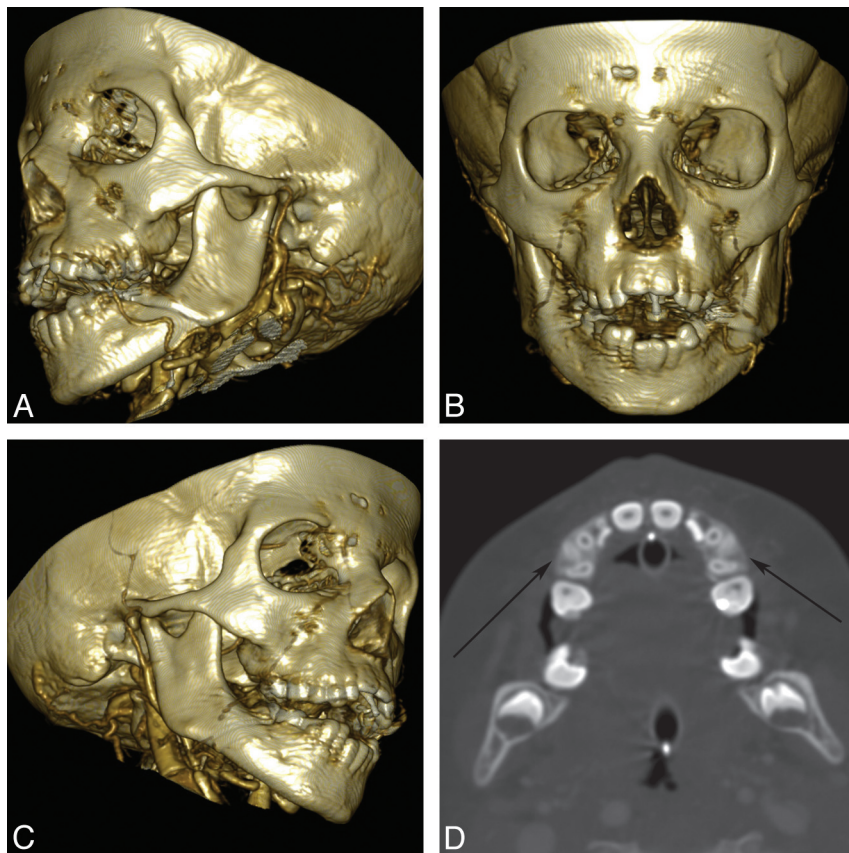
A 6-year-old boy with VCFS. A–C, 3D bone reconstructions show mild micrognathia with normal condyle and coronoid process morphology. D, Axial CT angiogram shows relatively symmetric micrognathia and areas of malocclusion (arrows).
